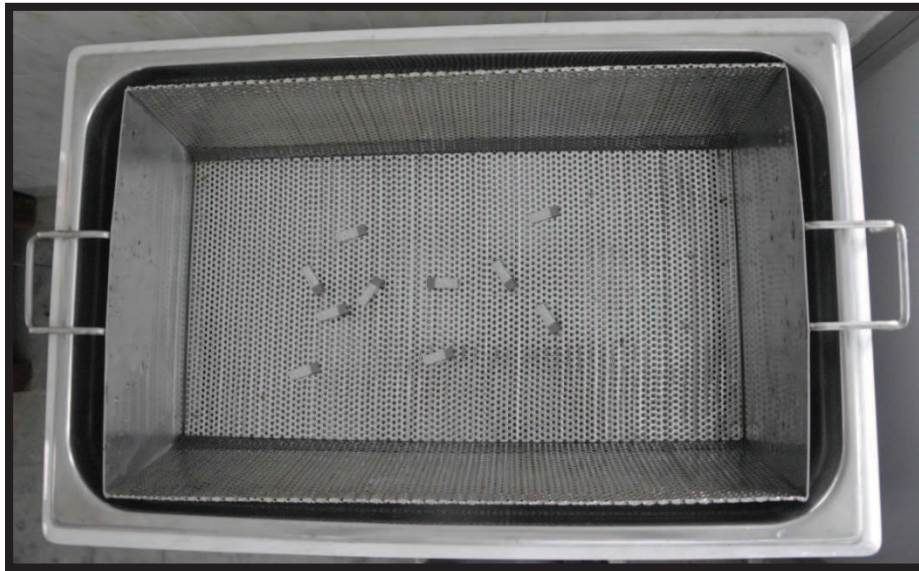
Sandblasted Cobalt-Chromium metal blocks in ultrasonic cleaner
